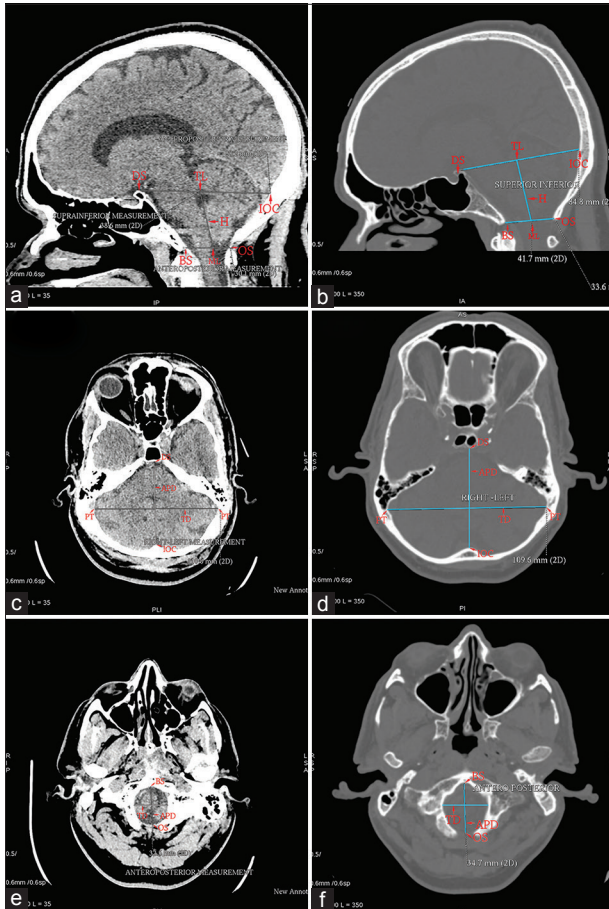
(a) Brain computed tomography midsagittal film demonstrating the boundaries of posterior fossa. (b) Brain computed tomography midsagittal film (bone window) demonstrating the measurement of height of the posterior fossa. DS – Dorsum sellae; IOC – Internal occipital crest; TL – Twining’s line; BS – Basion; OS – Opisthion; ML – McRae’s line; H – Height of posterior fossa. (c) Brain computed tomography axial film demonstrating anteroposterior and transverse diameters of posterior cranial fossa. DS – Dorsum sellae; IOC – Internal occipital crest; PT – Base of Petrous temporal; APD – Anteroposterior diameter; TD – Transverse diameter. (d) Brain computed tomography axial film (bone window) demonstrating the measurement of anteroposterior and transverse diameters of posterior cranial fossa. (e) Brain computed tomography axial film demonstrating anteroposterior and transverse diameters of foramen magnum. (f) Brain computed tomography axial film (bone window) demonstrating the measurement of anteroposterior and transverse diameters of foramen magnum. BS – Basion; OS – Opisthion; APD – Anteroposterior diameter; TD – Transverse diameter
